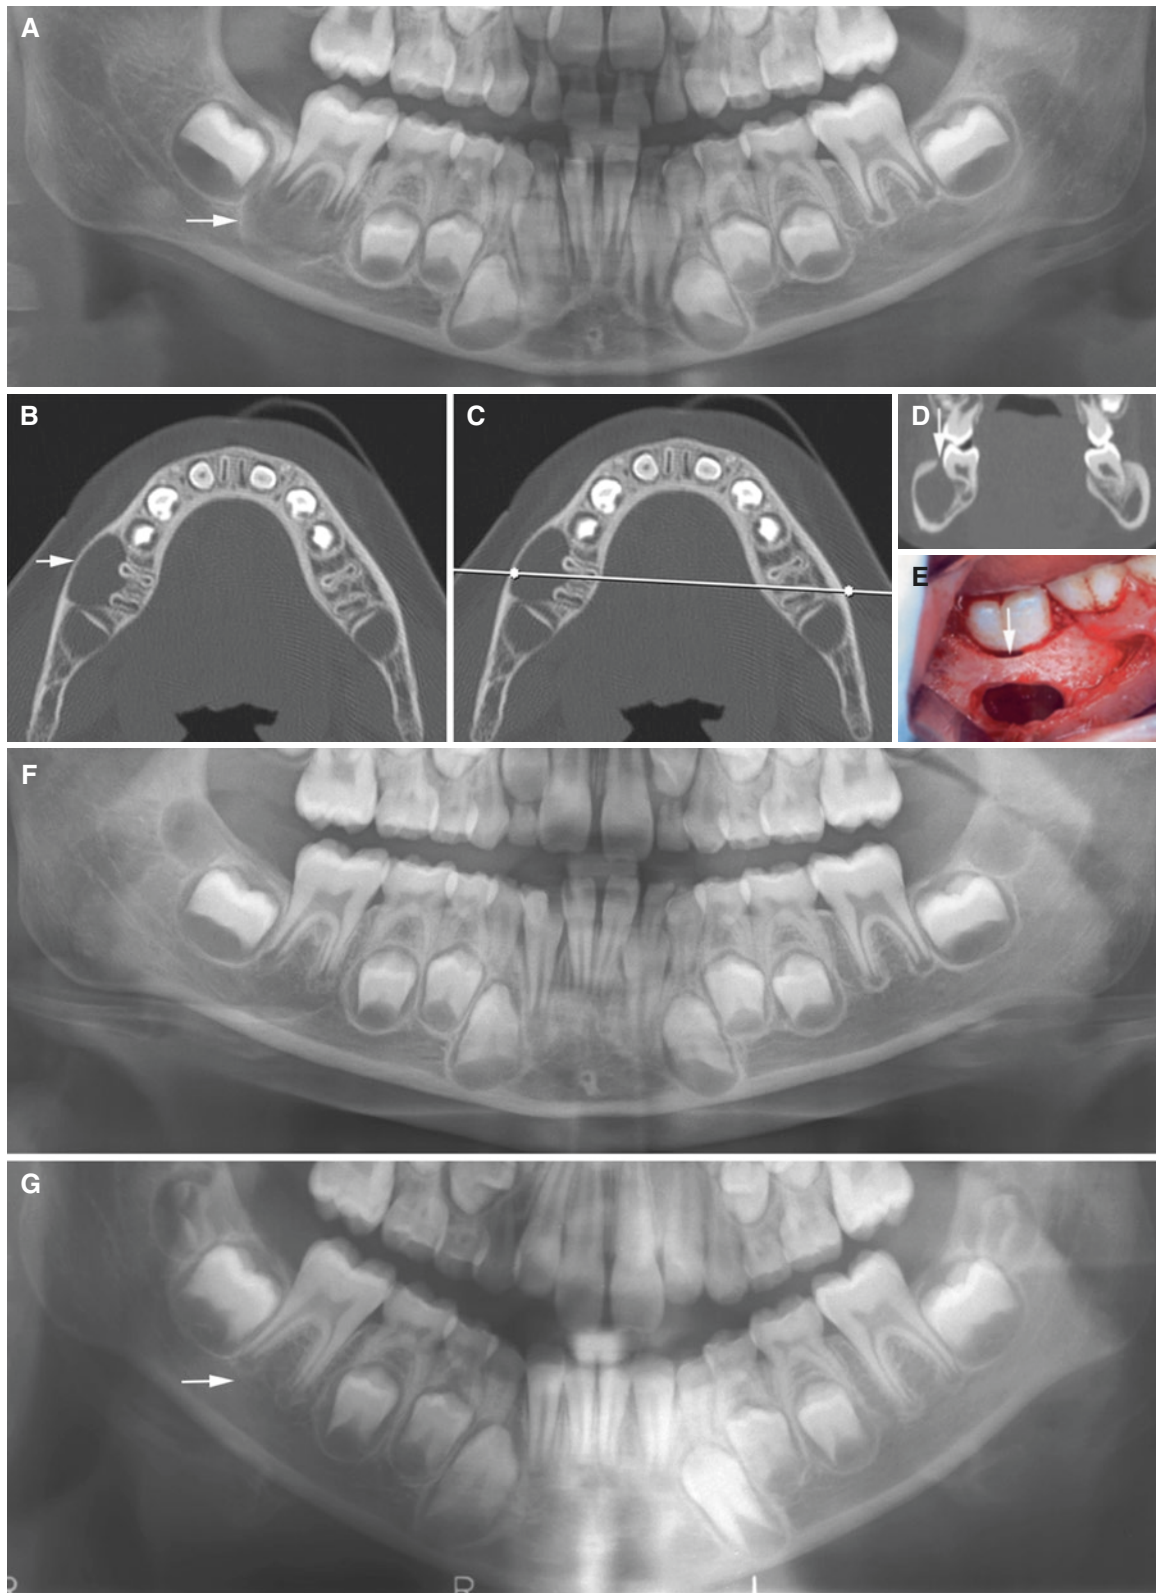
Paradental cyst, mandible; 7-year-old male with variable right-sided perimandibular swelling and pain. (A) Panoramic view shows radiolucency in root area of first molar (*arrow*). (B) Axial and (C) axial (with cursor line) CT images show buccally located radiolucency with expansion at first molar (*arrow*). (D) Oblique coronal CT
